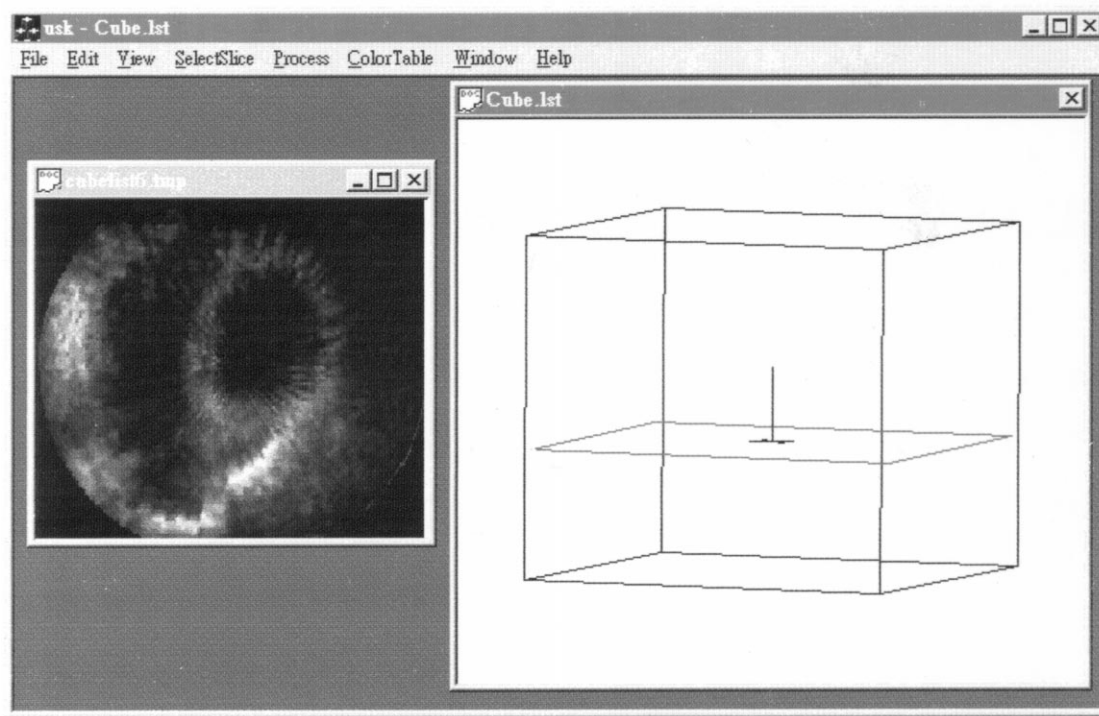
The reformation of 2D echocardiogram. On the right panel, the cube shows the re-coordinated cubic echocardiographic image data, the frame inside the cube and with a arrow attached on it is the resampled 2D frame, and the arrow displays the direction to resample the 2D echocardiograms. On the left panel, it displays the resultant 2D echocardiogram in the short-axis cutting plane.
